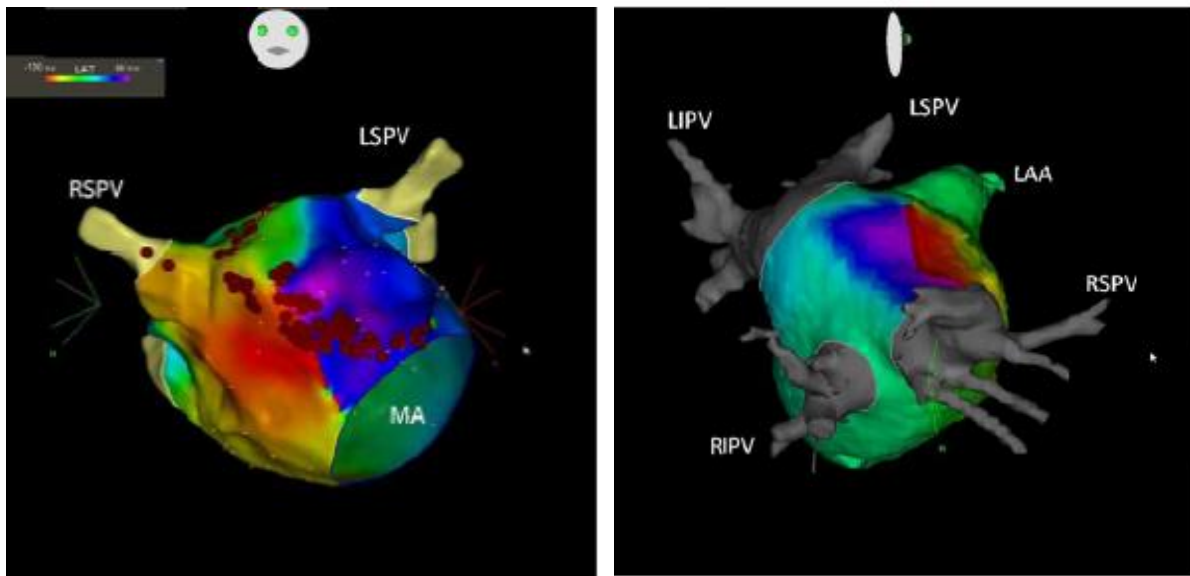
A Perimitral reentry propagating around the mitral valve in counterclockwise direction on three dimensional CARTO activation map. Red dots represent the ablation line which was created between the anterior mitral annulus and the right superior pulmonary vein. Pannel B Roof dependent flutter propagating around the right sided pulmonary veins on three dimensional CARTO activation map with CT integration in right lateral view. RSPV: right superior pulmonary vein, RIPV: right inferior pulmonary vein, LSPV: left superior pulmonary vein, LIPV: left inferior pulmonary vein, LAA: left atrial appendage, MA mitral anulus.
